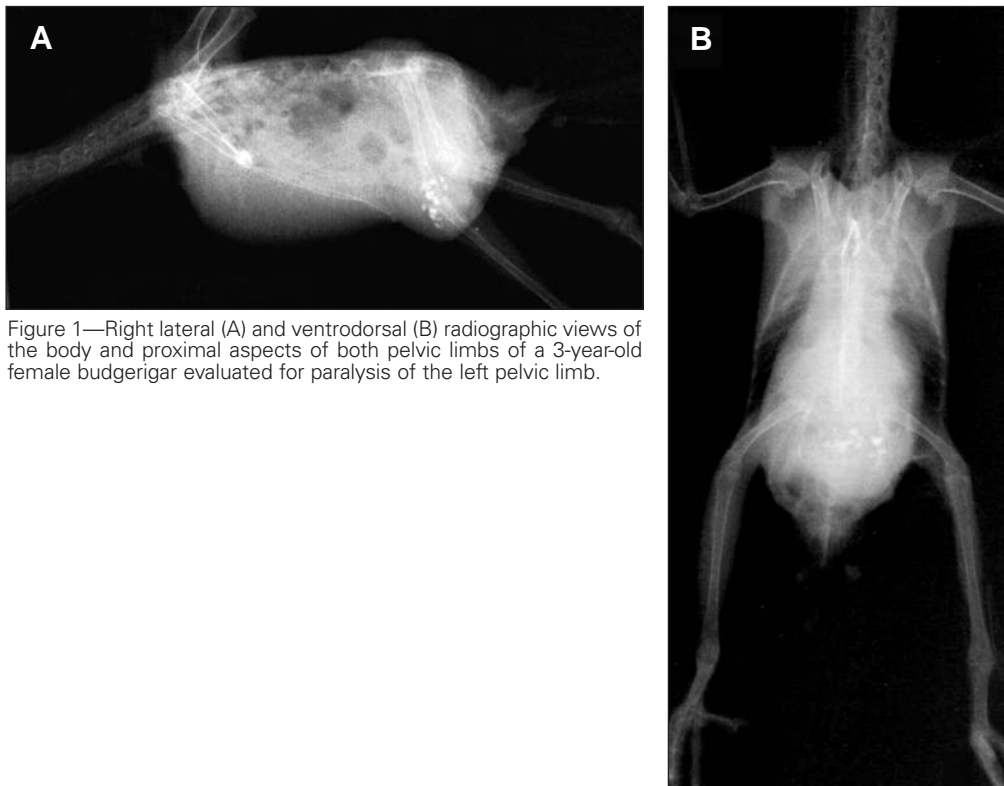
Right lateral (A) and ventrodorsal (B) radiographic views of the body and proximal aspects of both pelvic limbs of a 3-year-old female budgerigar evaluated for paralysis of the left pelvic limb.
